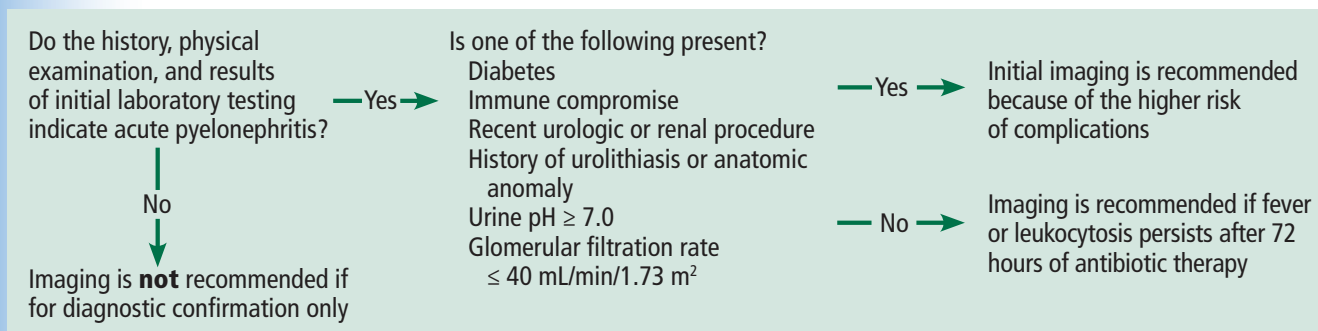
Pathway for considering imaging in acute pyelonephritis. The recommended imaging study is computed tomography of the abdomen and pelvis with contrast, or computed tomography without and with contrast. The choice may be tailored to the patient's clinical condition.
